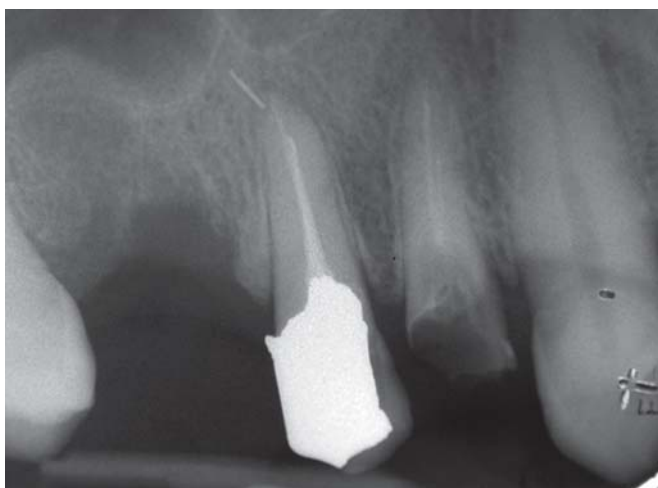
Osteotome SFE periapical radiograph of maxillary 2nd premolar indicated for extraction (broken endodontic file)
